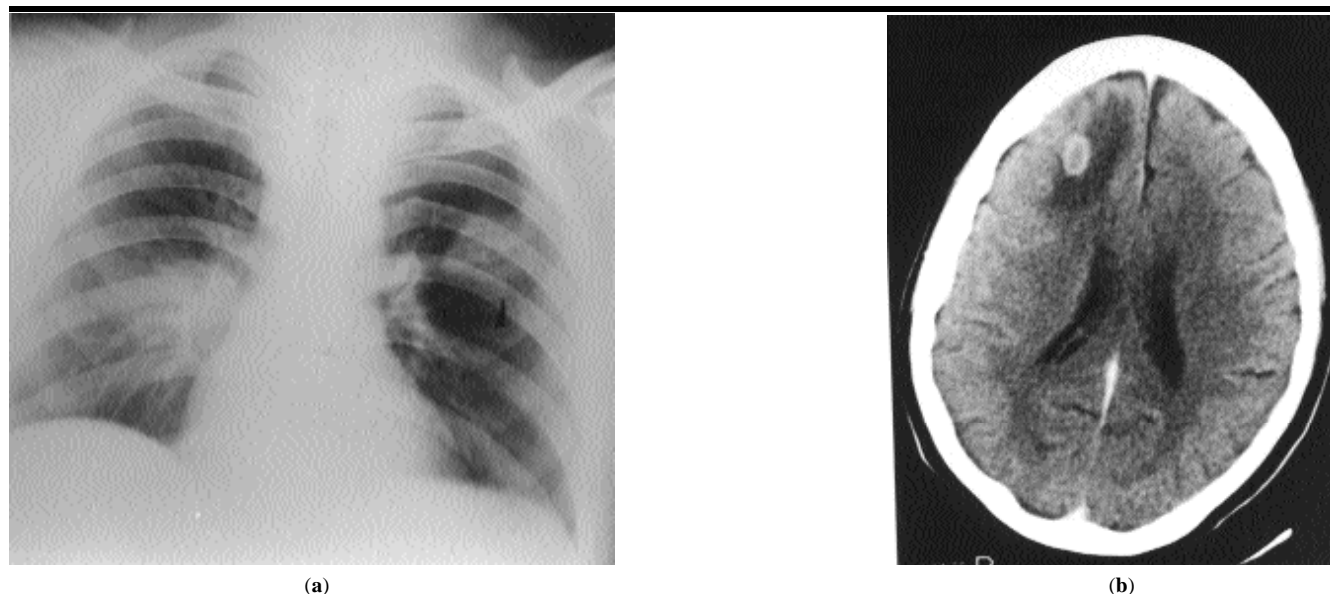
(a) A chest roentgenogram showing non-homogenous opacity in the right parahilar area and a consolidation in the middle zone of the left lung in case 2. (b) A cranial computed tomography showing brain abscesses in case 2.
